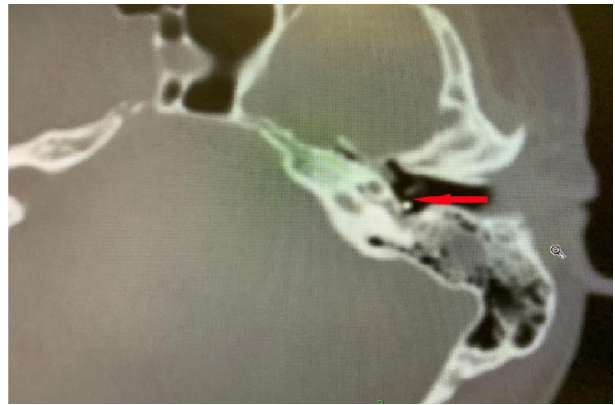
CT temporal bone showing metallic FB behind the tympanic membrane
